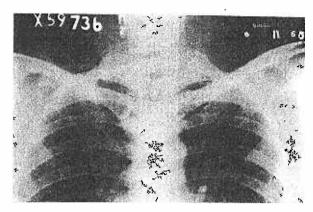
The Coraco-clavicular joints as seen on roentgenograms. The facets on both the clavicle and coracoid can be easily made out. Note also the enlargements of the conoid tubercles and the fact that it is the lateral sloping surfaces of these tubercles that articulate with the coracoid.
